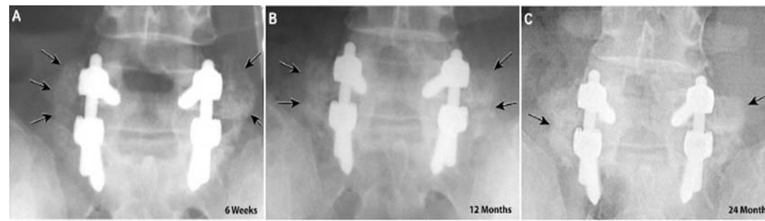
Radiographs of the fusion mass at 6 weeks (A), 12 months (b), and 24 months after posterolateral arthrodesis spinal surgery using a ceramic-granule bulking agent with rhBMP-2 loaded collagen sponge to mediate joint ossification. Radiographs show the initial presence of ceramic granules (arrows in A) which are later resorbed and replaced with new bone formation (arrows in B & C). (Reproduced from [91] with permission pending from Rockwater Inc.)
